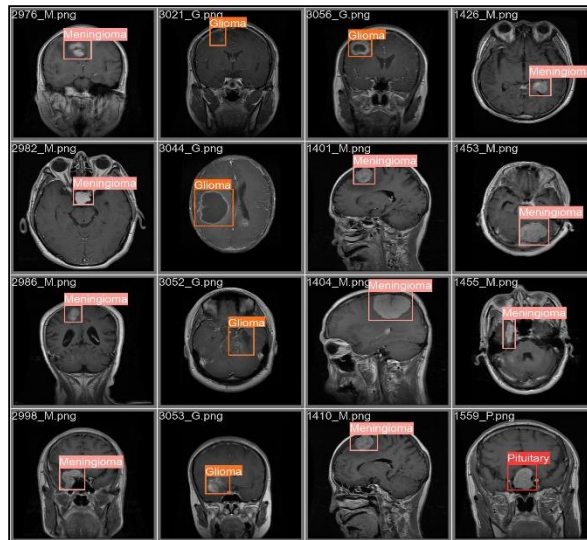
Processed MRI images by trained YOLO model.
